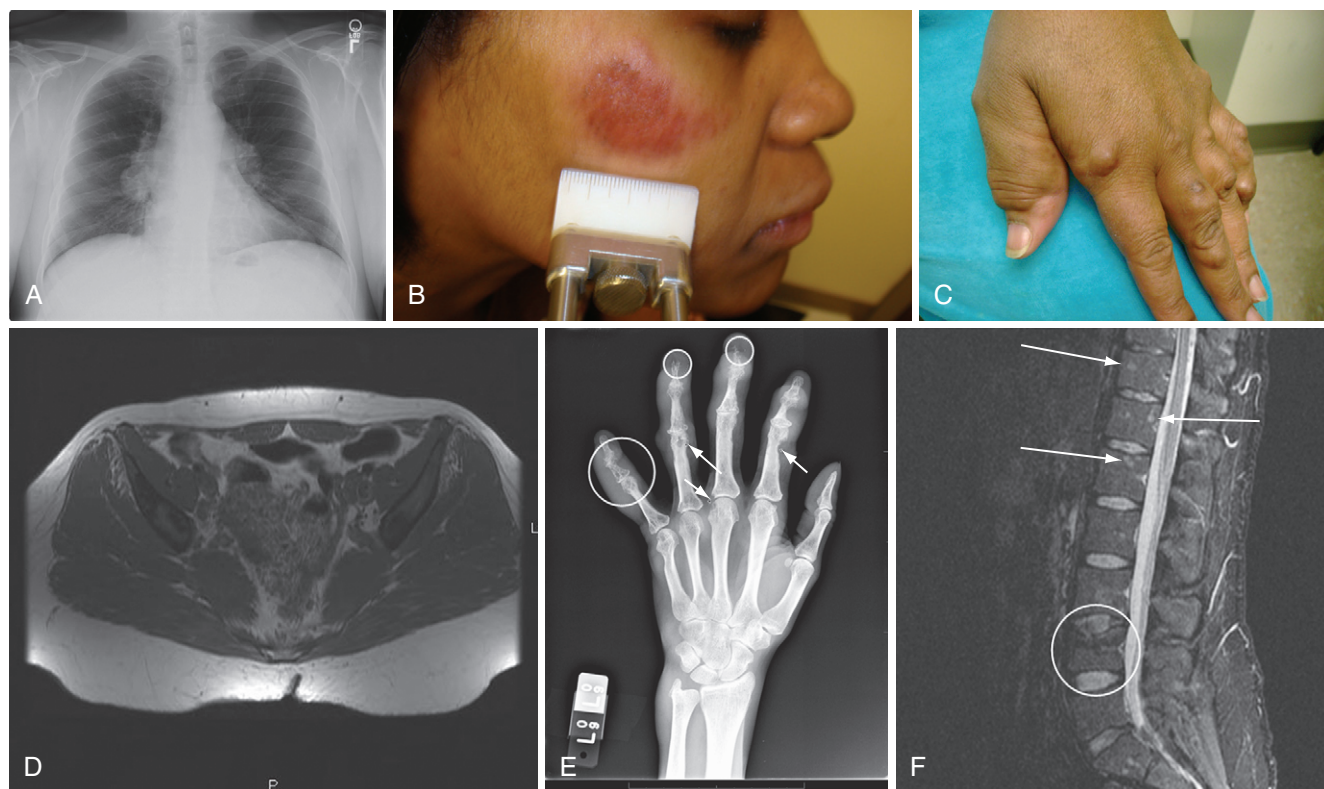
Various manifestations of sarcoidosis. A, Bilateral hilar adenopathy and right paratracheal lymph node enlargement demonstrated on a posterior anterior chest roentgenogram, Scadding stage 1.³⁸ B, Facial lesion consistent with lupus pernio.⁶⁰ C, Hand changes consistent with sarcoidosis in the fingers. D, Noncontrast magnetic resonance image of the pelvis demonstrating bone marrow replacement by granulomatous tissue. E, Cystic changes (arrows) within the bones of the fingers of a patient with sarcoidosis. F, Gadolinium enhancement of lesions of the spine seen on magnetic resonance image of a sarcoidosis patient. (B, Reproduced with permission from the patient.)
